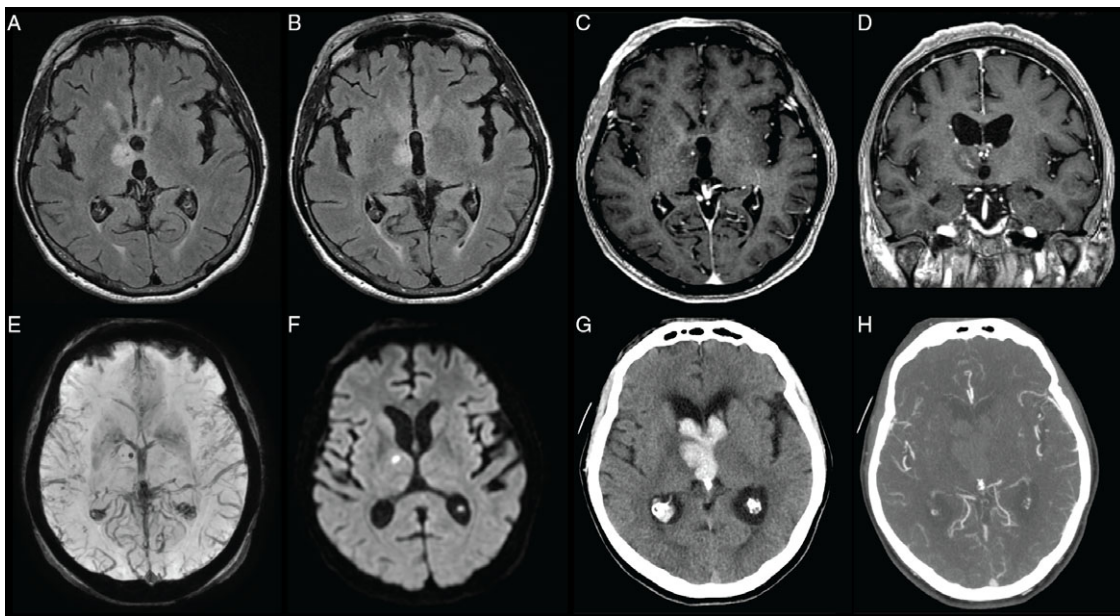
MRI day 20 and CT day 21. (A) Axial FLAIR image demonstrating resolution of changes of PRES. A hyperintense focus with a punctate central hypointensity is now seen in the anterior right thalamus. (B) Axial FLAIR image again showing resolution of PRES and new hyperintensity in the thalamus. (C) Post-gadolinium image. (D) Post-gadolinium coronal image showing enhancement of branching vascular structure within the lesion. (E) Susceptibility-weighted sequence shows corresponding hypointense thalamic focus, suggesting a possible area of microhemorrhage. (F) Diffusion-weighted image depicting diffusion restriction in a small portion of the thalamic lesion more laterally. (G) Non-contrast CT image demonstrating acute hemorrhage in the right thalamic lesion with intraventricular extension on day 21. (H) CT angiography shows no vessel abnormalities within the lesion.
